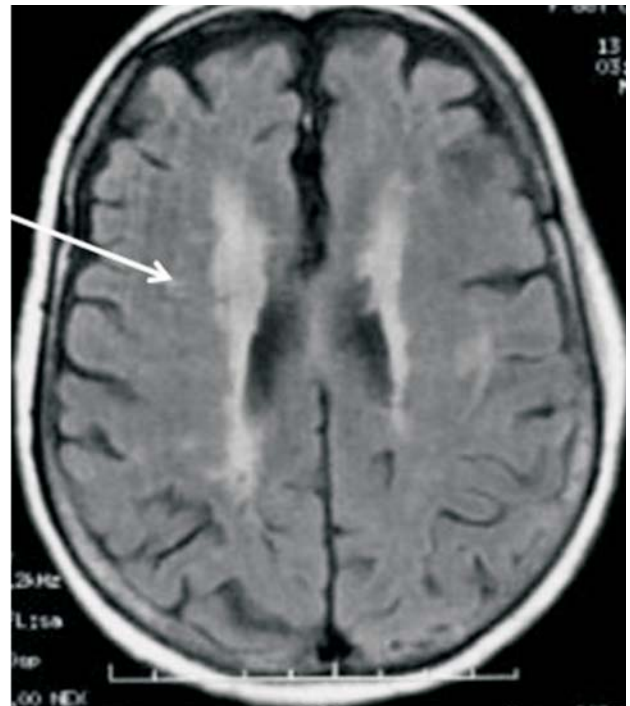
Magnetic resonance imaging of brain showing bilateral periventricular hyperintensities in the region of corona radiata and basal ganglia on T2 FLAIR.
